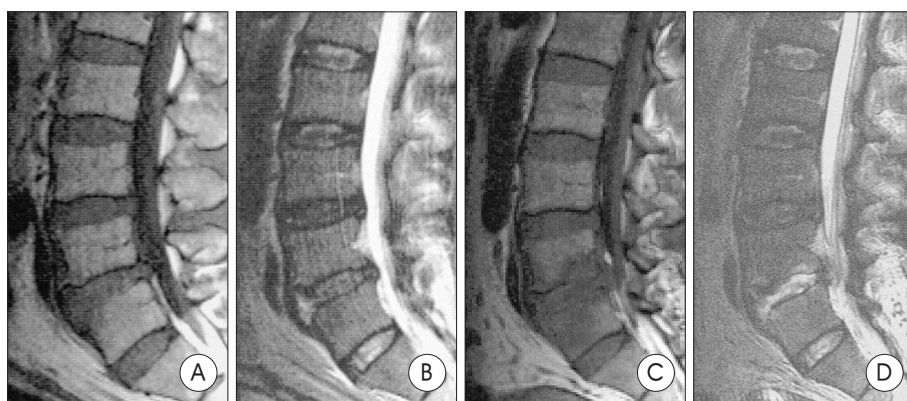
A, B : The initial magnetic resonance(MR) images of patient No. 5 at stage A1. There is no definite bony or signal change on the endplates and vertebral body, except for a slight signal difference in the anterior disc space on T2 WI. Definite diagnosis of the infection cannot be made by images at this stage. C, D : MR images of patient No. 5 at stage A2 two weeks later. The images have changed to a low signal on T1 WI (C) and a definite high signal intensity on T2 WI (D).
